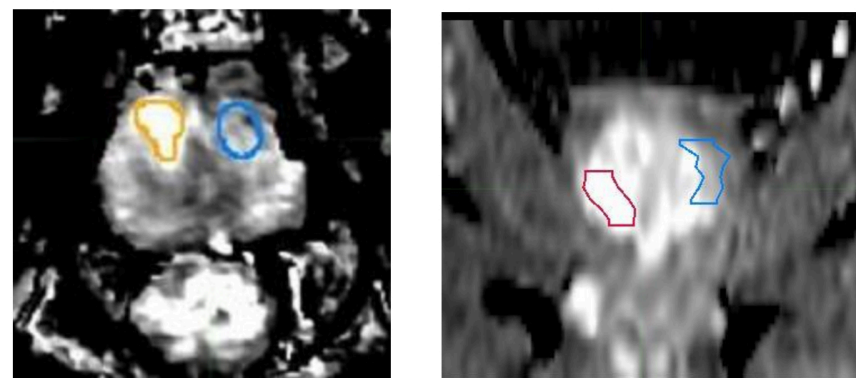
(a) is the axial view of the K_{ep} calculated image. The next image is the coronal view of the K^{trans} MR image. The blue contour is the NP, red contour is the K^{trans} delineated DIL, and the orange contour is the K_{ep} DIL contour. Hyperintense areas on these images correlate to high transfer value in (K^{trans}) and out (K_{ep}) of the region, which indicate higher microvascular permeability (common to tumors).
